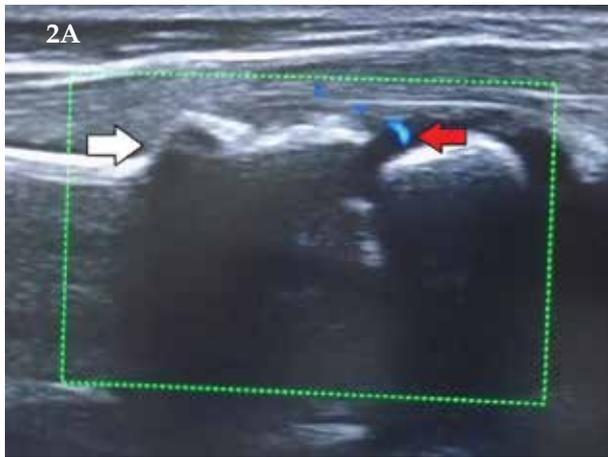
Ultrasound picture of a buckle fracture (white arrow) and the nutrient vessel (red arrow). 2b. X-Rays of the above mentioned fracture
